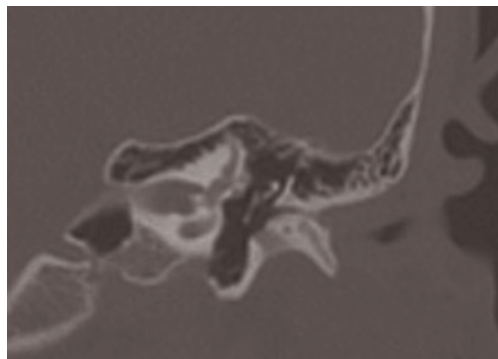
Coronal CT scan. Stenosis of the bone portion of the left external auditory canal.
